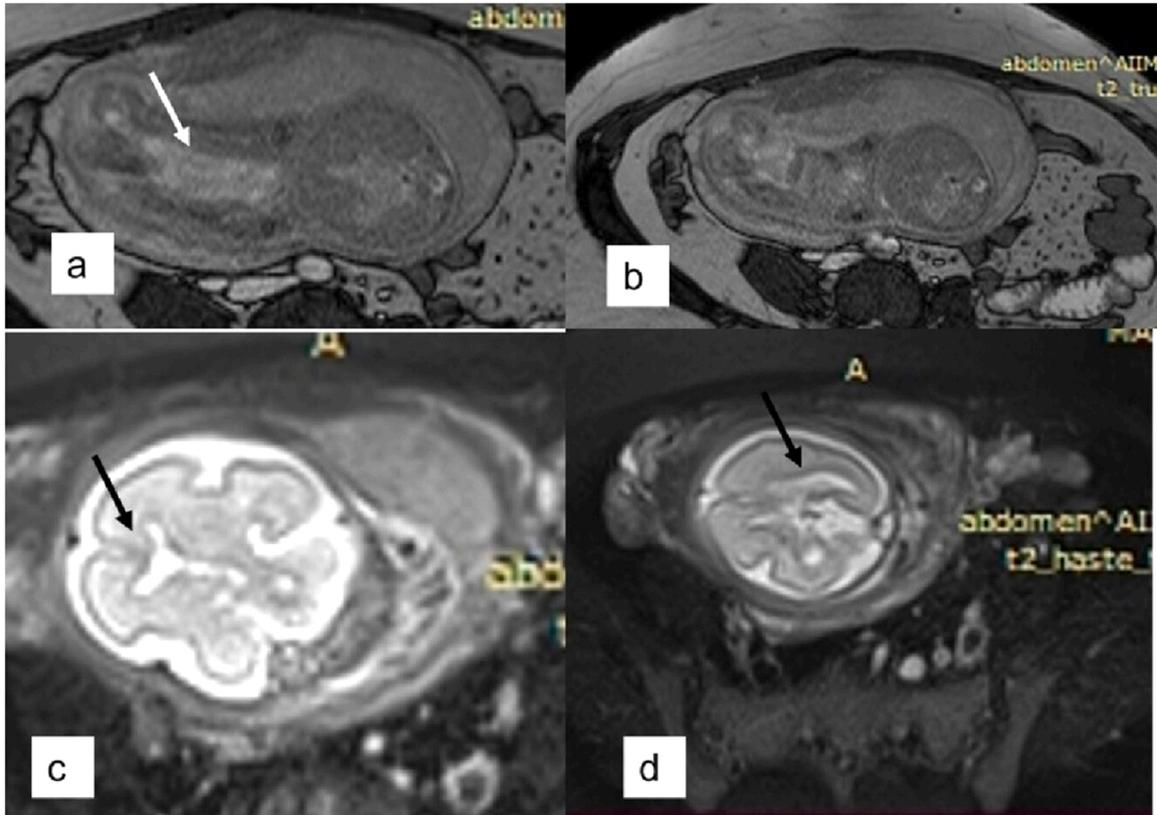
Fetal MRI (a) T2w axial scan HASTE sequence depicting the hyperintense soft tissue in between lower limbs (arrow) suggestive of soft tissue sirenomelia. (b) Axial T2w axial scans Tru Fi sequence show absence of bilateral Kidneys. (c and d) Axial T2w TruFi sequence show Viking helmet sign (arrow in c) and bilateral parallel ventricles suggestive of corpus callosal agenesis. Anhydramnios is present. [HASTE–Half fourier Single-shot Turbo spin-Echo; Tru Fi: True Fast Imaging].
